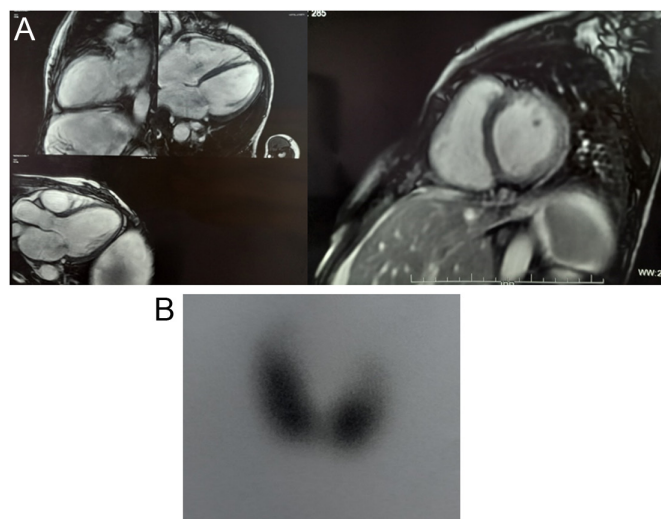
(A) Cardiac magnetic resonance imaging showing biventricular dilatation. (B) Tc99m scintigraphy of the thyroid showing an intense and homogeneous uptake in relationship with Graves' syndrome.
